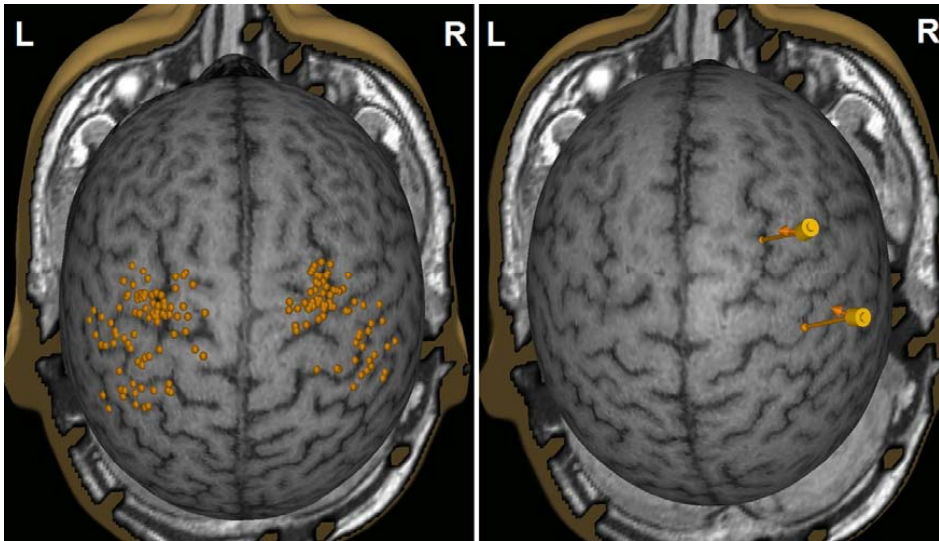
All the stimulation points, indicated with orange dots, evoking responses in OP muscles (left) and the optimal left OP muscle representations in M1 and in NPMA in the non-dominant hemisphere of one subject (right). Yellow cylinders show coil locations and small arrows direction of induced current. Three-dimensional head MRI is peeled and cerebral cortex is shown from above. L = left, R = right.
